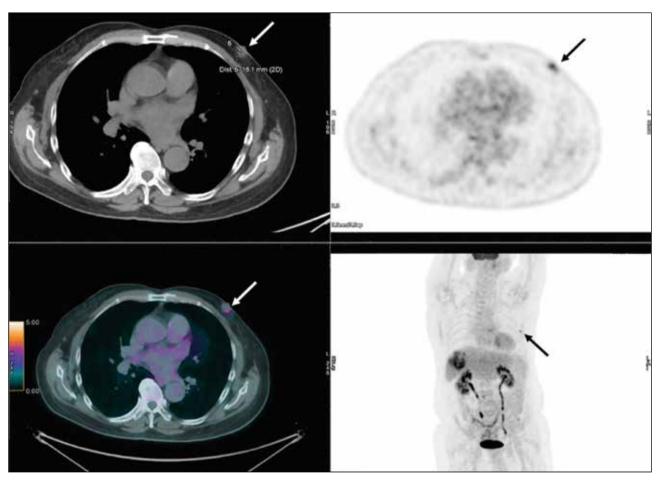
Positron emission tomography–computed tomography of the patient for colon cancer workup incidentally revealed a 1.6-cm hypermetabolic lesion at the subareolar region of the left breast (arrows).
